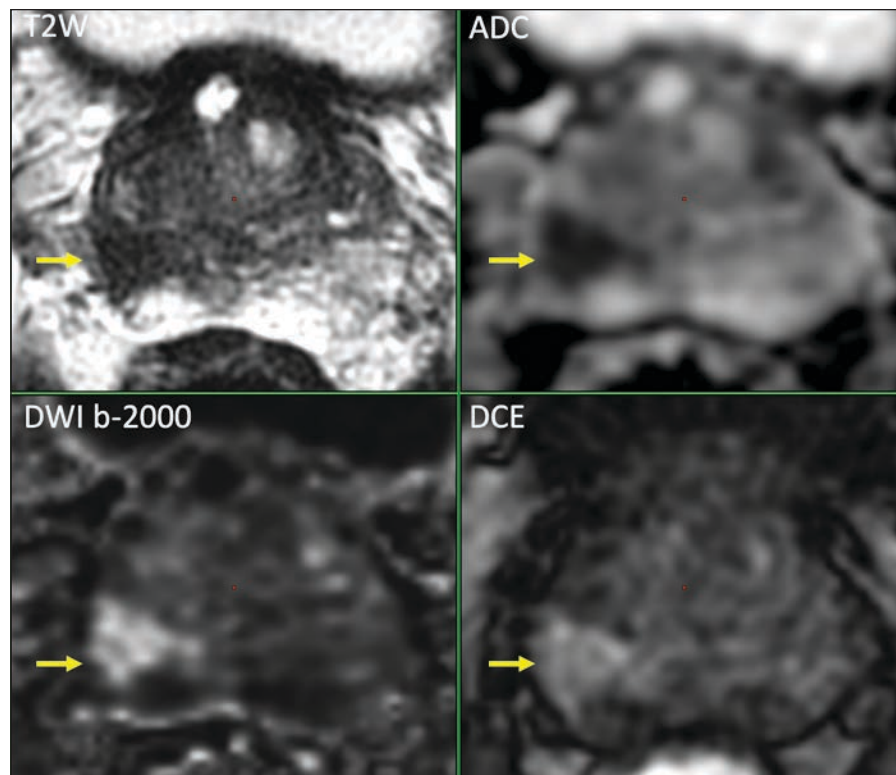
DCE-MRI does not add value in larger lesions with PI-RADS 4 or 5 scores in non-contrast MRI. 72 year-old man, cT1, PSA 8.1 ng/ml, Pvmri 36 ml, PSAD 0.23 ng/ml², primary diagnosis. Suspected lesion of 16 mm right peripheral zone with PI-RADS score 5 (T2W:5, DWI/ADC:5, DCE:+). DCE did not add value in this large PI-RADS 5 lesion. Three MRI-directed fusion biopsies revealed Gleason score 3+4=7 (ISUP grade 2) without cribriform / intraductal growth.
